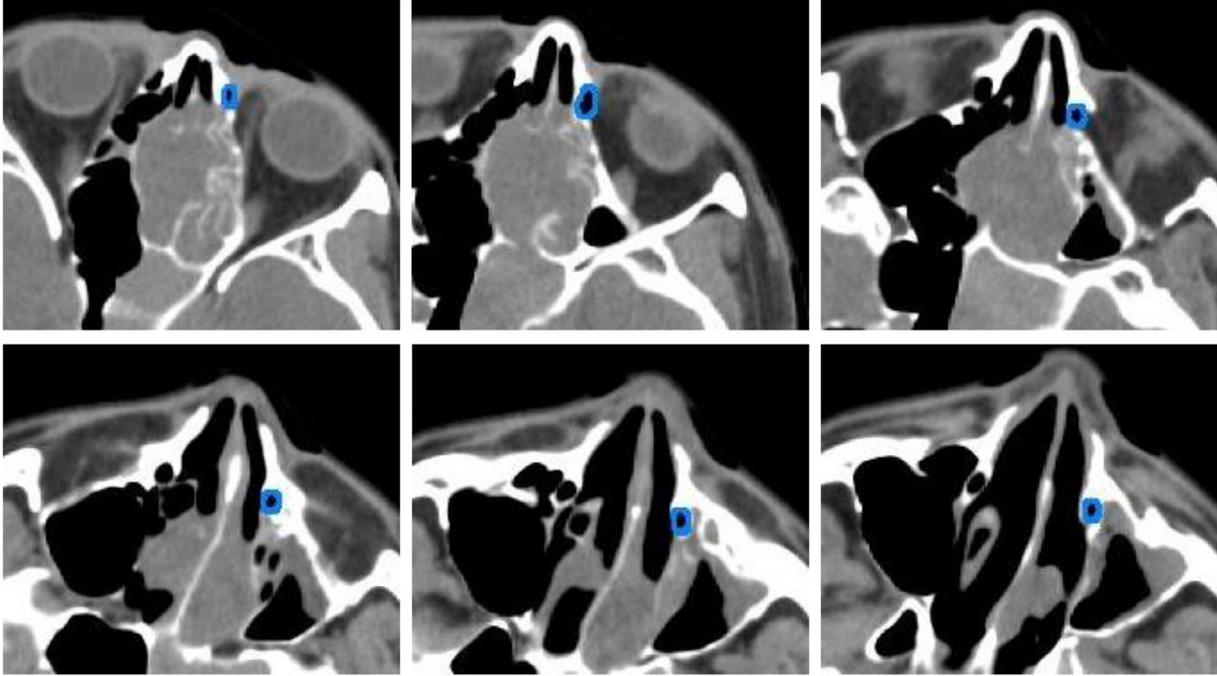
Representative computed tomography images used for delineation of the nasolacrimal duct. The nasolacrimal duct is indicated in blue.
